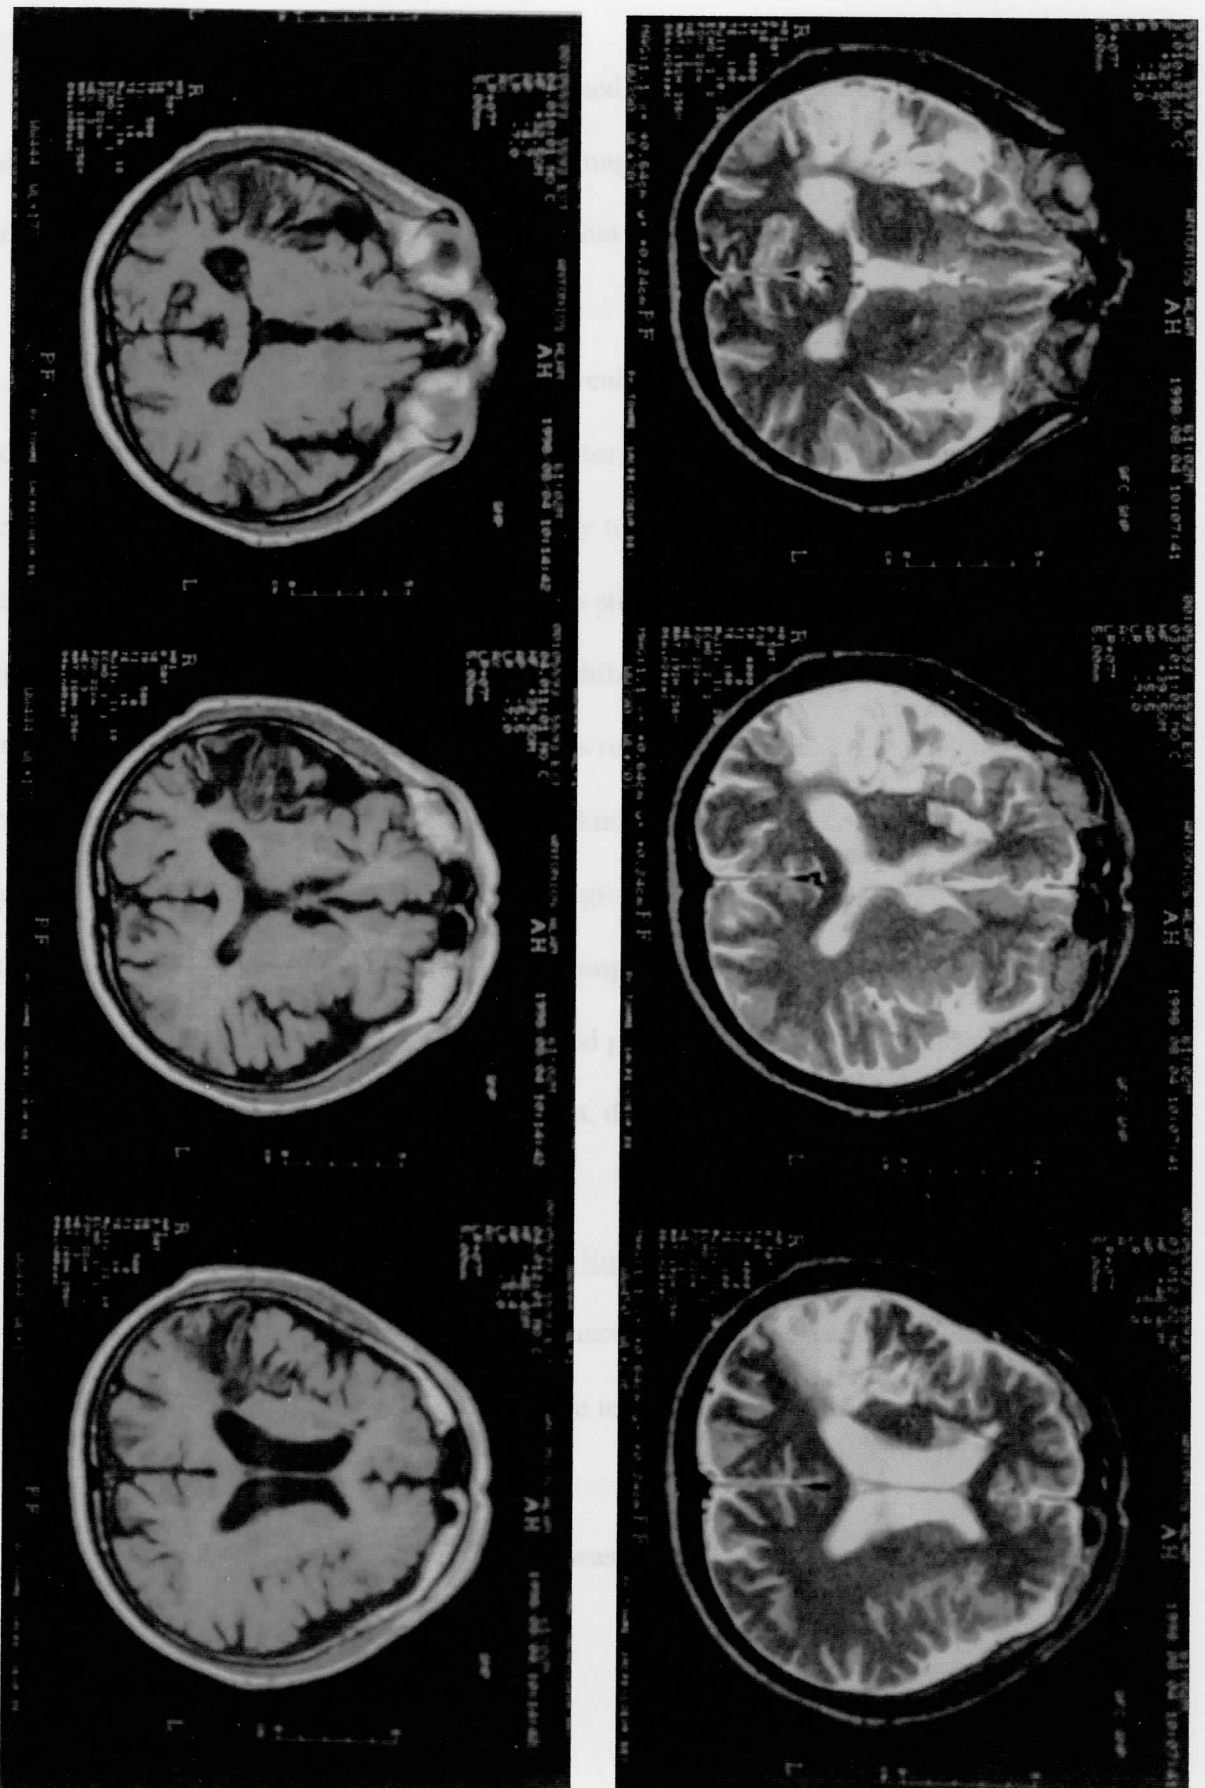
The MRI of T.A.'s brain showing a deep right CVA of the middle cerebral artery involving the frontal, parietal and temporal lobes.
